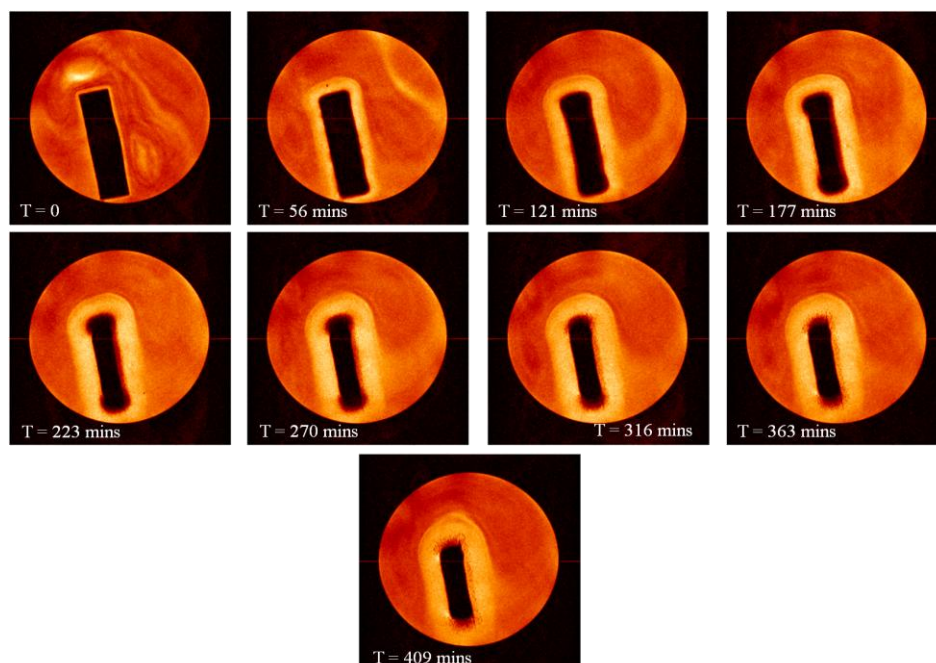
Series of magnetic resonance images acquired during 409 minutes dissolution time performed in USP 4 type flow through cell for press coated tablet with expected predicted lag time 5 hours containing HPMC E50LV as an outer barrier layer and theophylline as an active ingredient in inner core tablet (PLT-5 press coated tablet: diameter 13mm and thickness 3.42mm)
